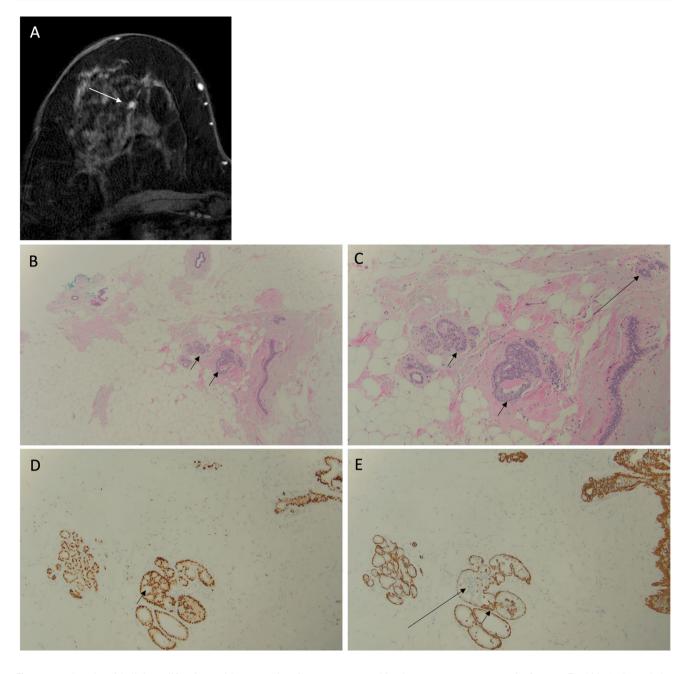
Intraductal epithelial proliferation without atypia. Contrast enhanced T1-weighted fat saturated image from a breast MRI showed a focus of enhancement in the right breast (A, arrow). On low power (B, 40×), the right breast biopsy showed a focus of intraductal epithelial proliferation (short arrows). On higher power (C, 100×), this focus is seen to be comprised of a monotonous population of cells (short arrows). Of note, the background glandular epithelium appears
